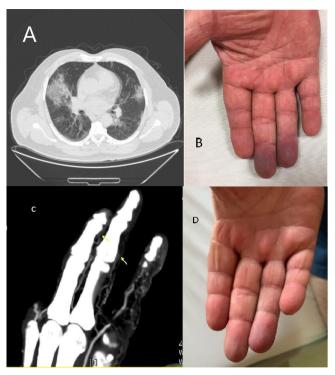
Selected computed tomography (CT) of the patient. CT of the thorax (A) and upper extremity angiography (C). (B) view of the patient's right hand on the day of thrombosis, (C) an abrupt occlusion of the radial artery is evident on angiography, yellow arrow indicates the thrombosis level and (D) view of the patient's right hand on the day of discharge from the hospital.
